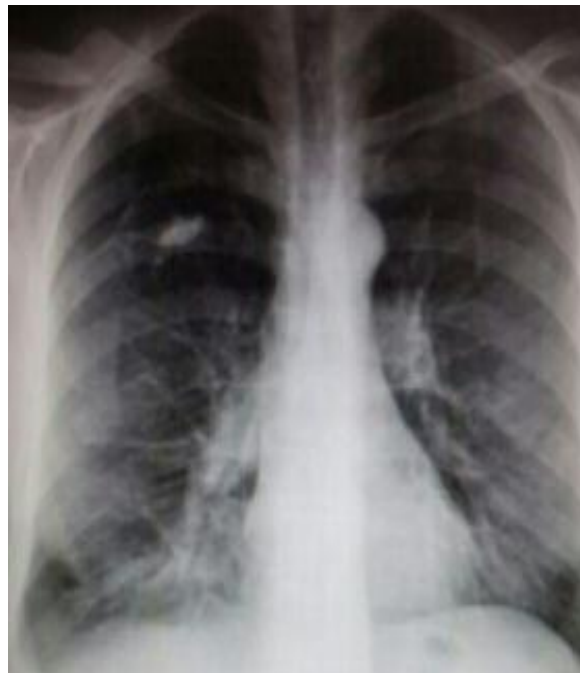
Preoperative chest radiography
